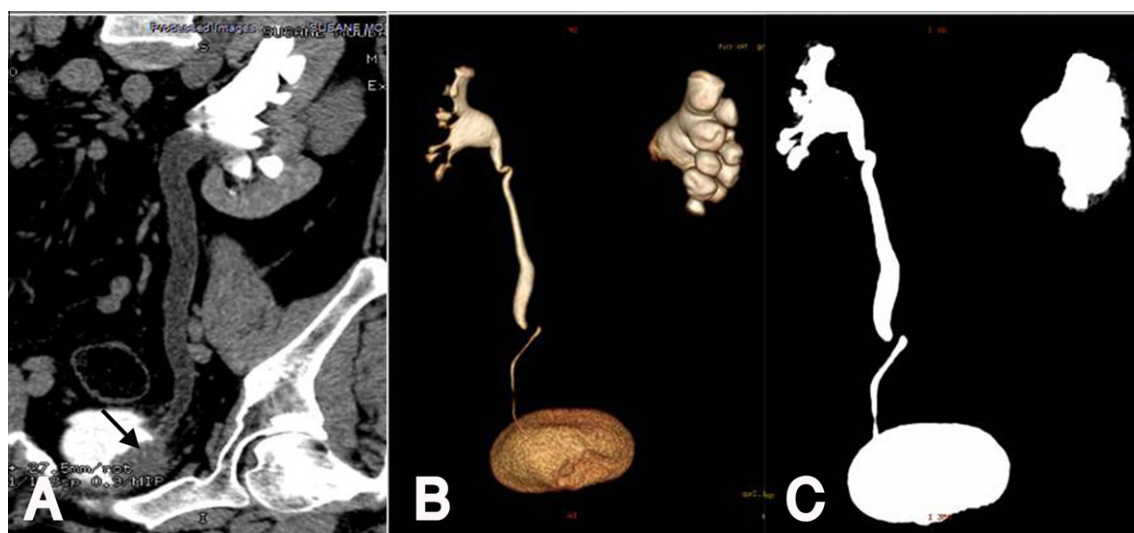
Sixty-five year old male presented with hematuria. Coronal CPR (A) in excretory phase shows left hydroureteronephrosis with a UB mass obstructing the left ureteric orifice (black arrow). Reconstructed coronal VR (B) and its corresponding MIP (C) images in excretory phase of CT urography failed to delineate the cause and level of ureteral obstruction as the dilated left ureter was not seen, also the UB mass was obscured by the high density contrast in the UB.
